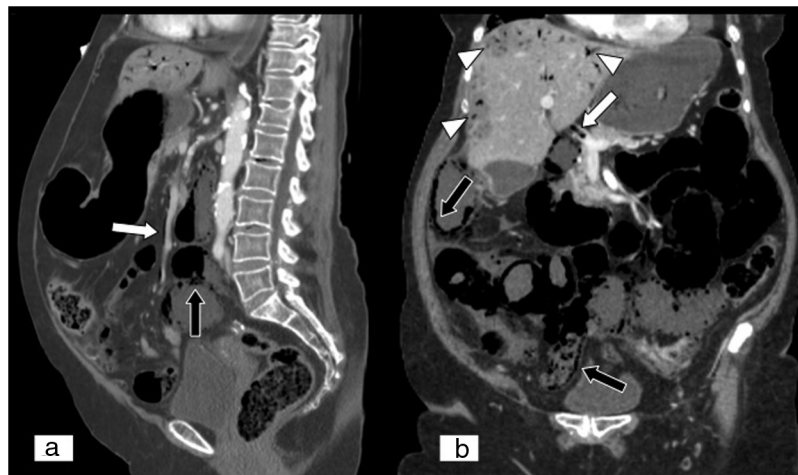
Intestinal pneumatosis and portomesenteric venous gas. MPR on a sagittal plane (A) and MPR on a coronal plane (B) of an abdominal and pelvic CT scan with iodinated intravenous contrast in a portal phase. An 85-year-old patient who sought care due to abdominal distension, tympanism, diffuse abdominal pain and signs and symptoms suggestive of bowel obstruction for the past 24 h. Gas in superior and portal mesenteric veins (white arrows) extending to intrahepatic portal branches and arranged peripherally (white arrow tips), unlike the presence of gas in the bile ducts (aerobilia). Absence of uptake in the intestinal wall and pneumatosis (black arrows). All this in a context of an intestinal ischaemic process.
